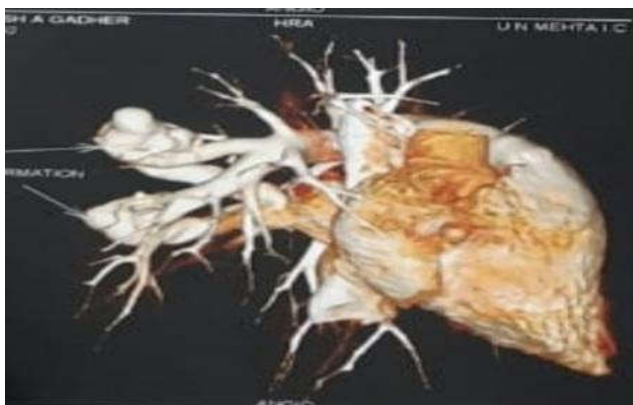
CT pulmonary angiography showing two lobulated well marginated enhancing lesions measuring 27mm x 26mm and 23mm x 22mm with large feeding arteries.
